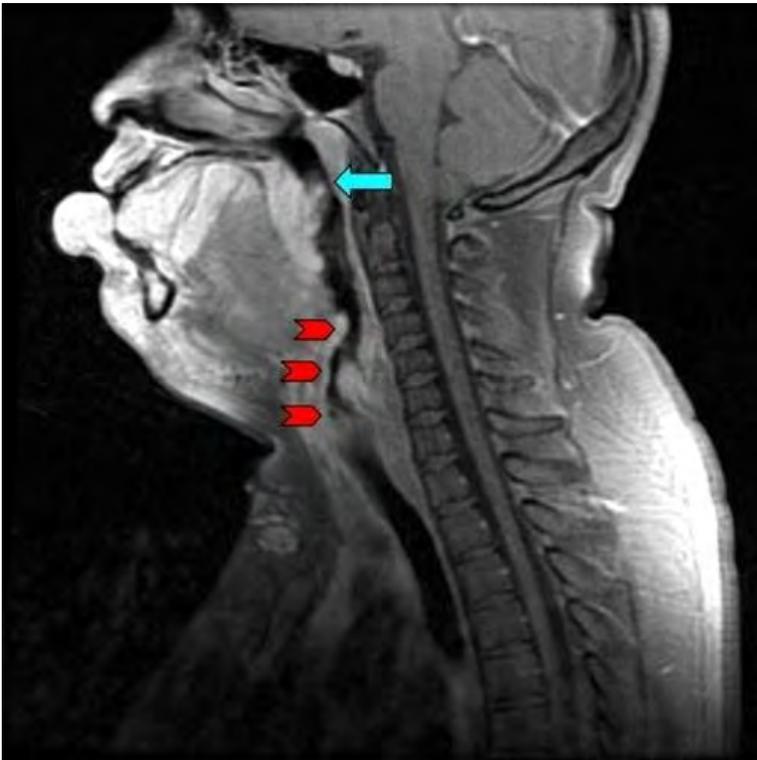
Sagittal T1 post contrast MRI. Vascular malformation of the lower lip, tongue, and aerodigestive tract to the larynx. Multifocal stenosis of airway (red arrows). Narrowest point of oropharyngeal stenosis measuring 10 mm x 3 mm (blue arrow).
